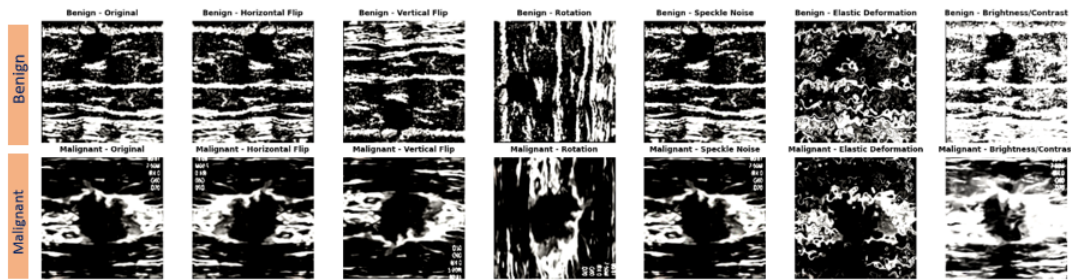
Ultrasound Augmentation
